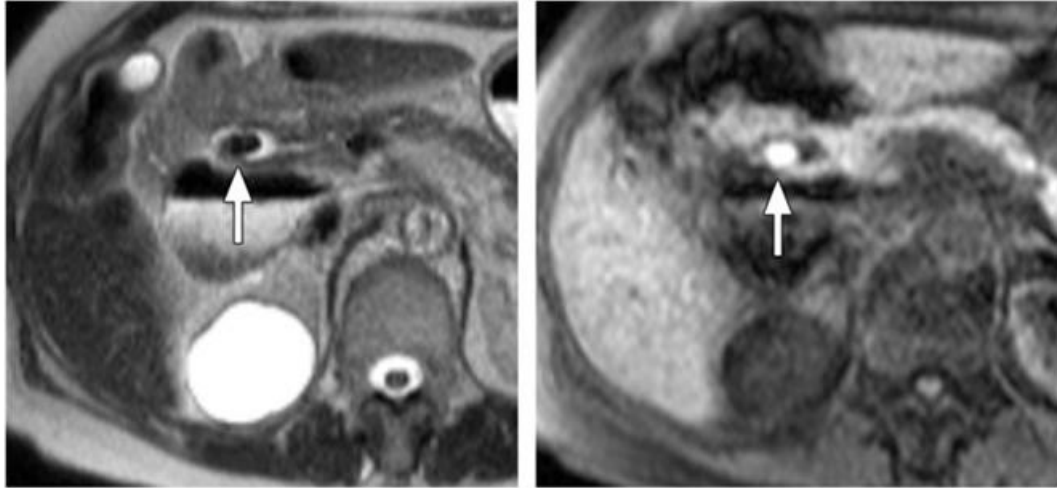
Bile duct stone identified by MRCP images. The stone appears as hypo-intense on a T₂-weighted MR image (l), but is hyper-intense on a T₁-weighted image [Yeh, 2009].
